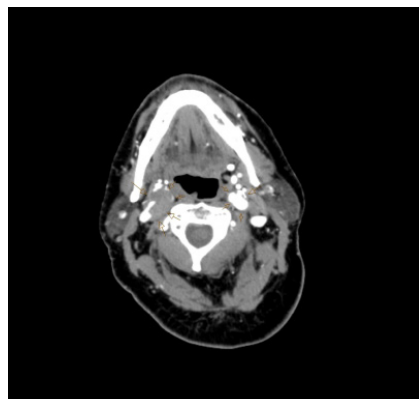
Axial CTA of the neck demonstrating bilateral ICA pseudoaneurysms that contain eccentric mural thrombus/atherosclerotic plaque.
